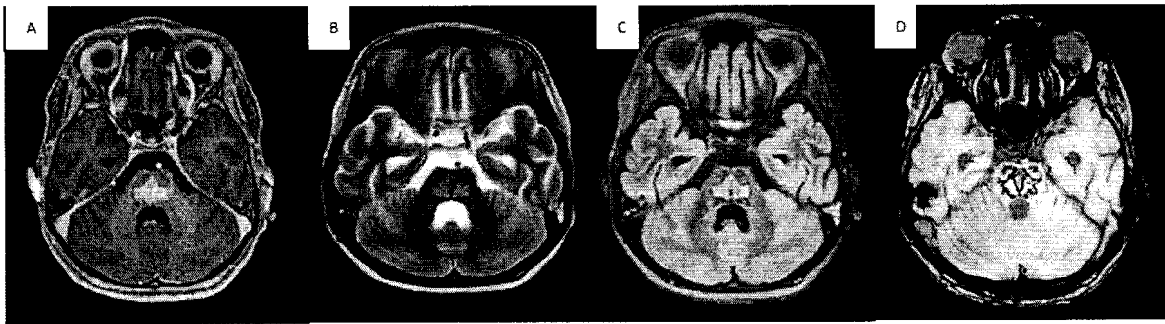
Contrast enhanced MRI brain performed at 4th week of illness showed hyperintense pontine lesion in Axial T1, T2, FLAIR images (A,B,C), signal drop with blooming effect on SWI images (D) .
